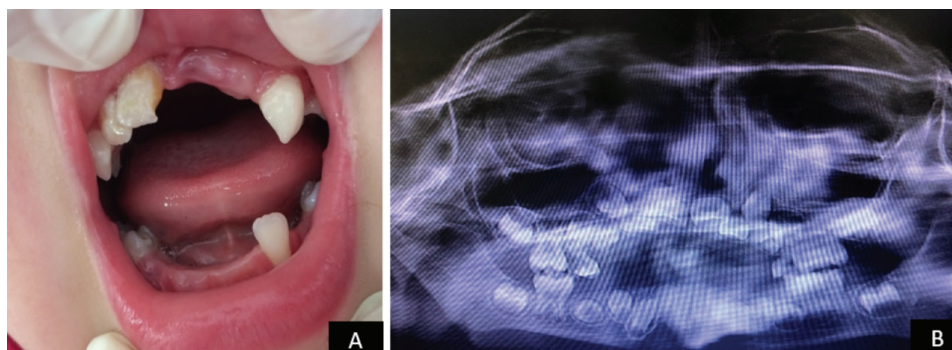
Intraoral appearance at diagnosis (A) and panoramic X-ray image at the 4th year of treatment (B)
